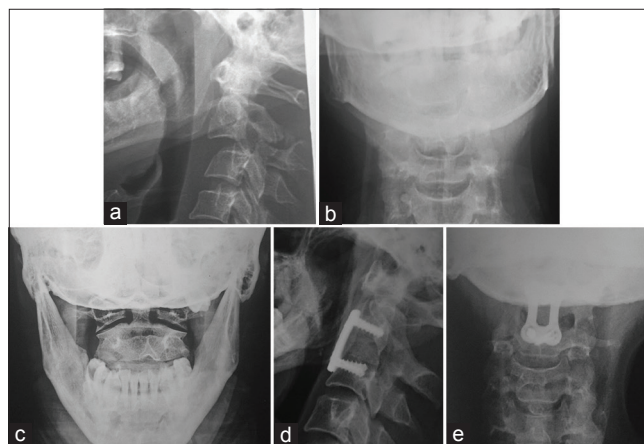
(a-c) Pre operative X-rays of Hangman's fracture (Levine and Edward Type II). (d and e) Six month follow up showing fusion (Bridwell fusion Grade 1)
